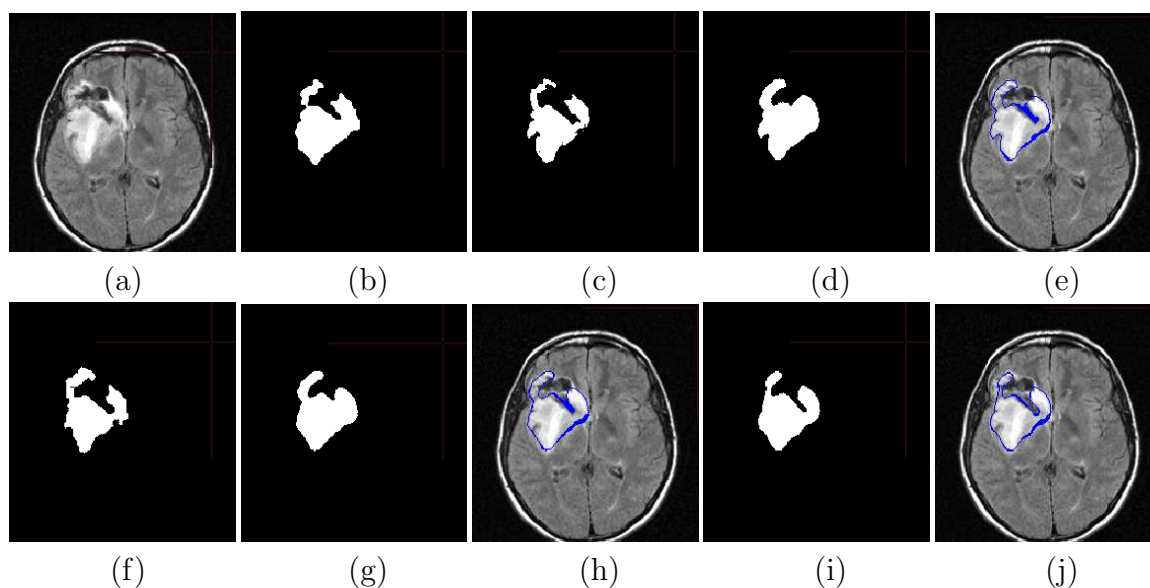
Comparaison des segmentations manuelle et automatique obtenue en utilisant l’analyse de symétrie et MPFCM pour une tumeur dans une image FLAIR. (a) Image originale. (b) Segmentation manuelle. (c) Segmentation initiale par MPFCM. (d) Segmentation raffinée de MPFCM. (e) Résultat superposé à l’image originale. (f) Segmentation initiale par analyse de symétrie. (g) Segmentation raffinée d’analyse de symétrie par le modèle déformable sans relations spatiales. (h) Résultat superposé à l’image originale. (i) Segmentation raffinée d’analyse de symétrie par le modèle déformable avec des relations spatiales. (j) Résultat superposé à l’image originale.
